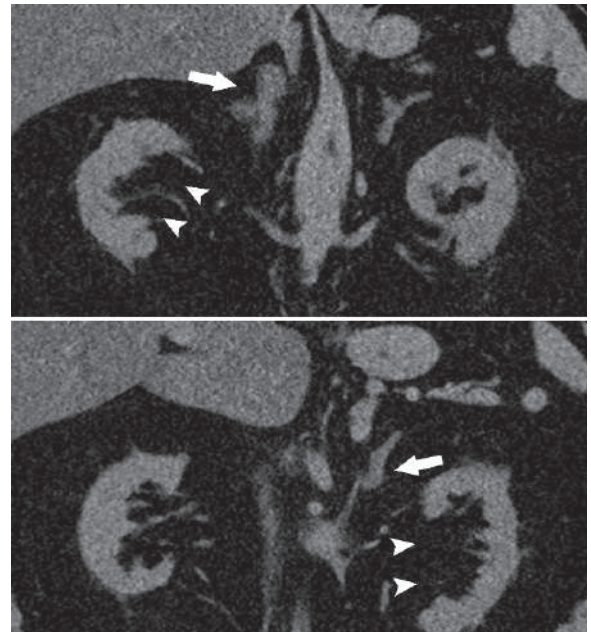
Coronal sequential nonenhanced CT images of another patient with Cushing's syndrome (CS) show bilateral renal pelvis lipomatosis (*arrowheads*), and bilateral adrenal hyperplasia (*arrows*). Notice how the right adrenal gland is markedly thickened
